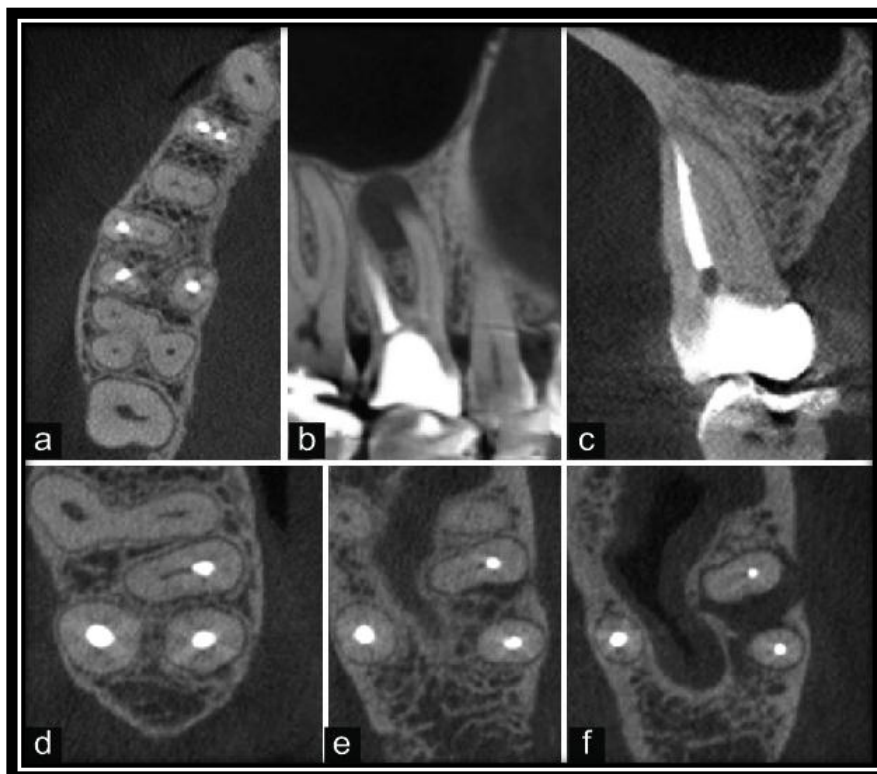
CBCT scan of the left first maxillary molar showing the presence of second canal in mesiobuccal root in axial, coronal and sagittal plane
